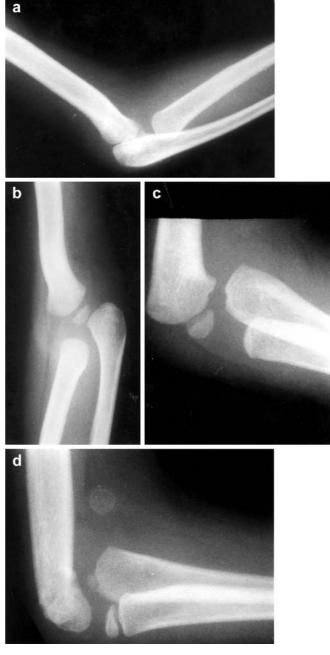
Serial radiographs of the elbow. a Lateral view at 1 year of age. b AP and c lateral views at 2 years of age. d Lateral view at the age of 4 years showing anterior dislocation of the ulna, abnormal angulation of the capitellum and an abnormal ossification centre
